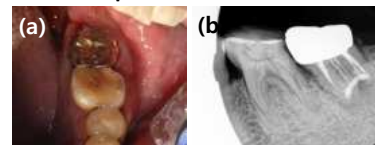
(a) 2 weeks intra-oral photograph (b) 2 weeks follow-up periapical radiograph
